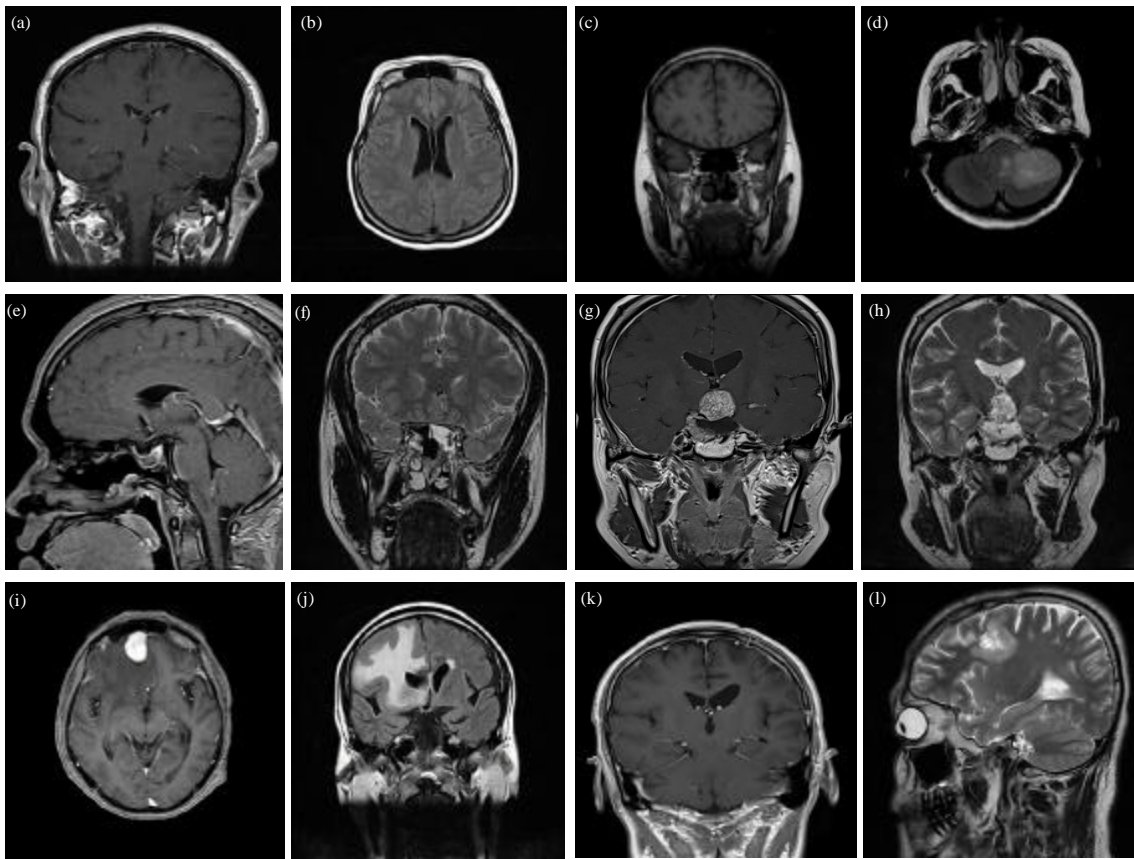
(a-l): Examples of axial sequences in (a-b) Normal and (c-l) Abnormal brain MRI image. (a) Normal, (b) T1-axial at Sequence 9, T2-axial at sequence 14, (c) Grade 1 meningothelial meningioma, (d) T1-axial at sequence 15 T2: T2-axial at sequence (15), (e) Grade 1 pituitary adenoma, (f) T1-axial at sequence 59 T2-axial at sequence 1, (g) Grade 2 diffuse astrocytoma, (h) T2-axial at sequence 8, T2-axial at sequence 10, (i) Grade 3 rhabdoid meningioma, (j) T1-axial at sequence 8 T2-axial at sequence 9, (k) Grade 4 medulloblastoma T1-axial at sequence 9, (l) T2-axial at sequence 13. (1) T1\_axial (2) T2\_axial. Source: Collected data from UKM Medical Center, Malaysia
